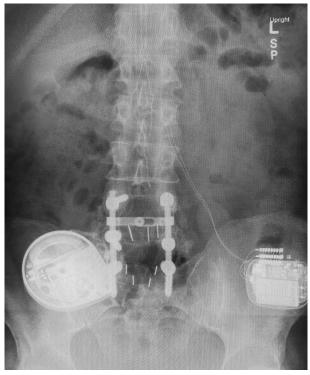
An x-ray of the patients's lumbar spine showing previous hardware, spinal cord stimulator, and intrathecal pump.
